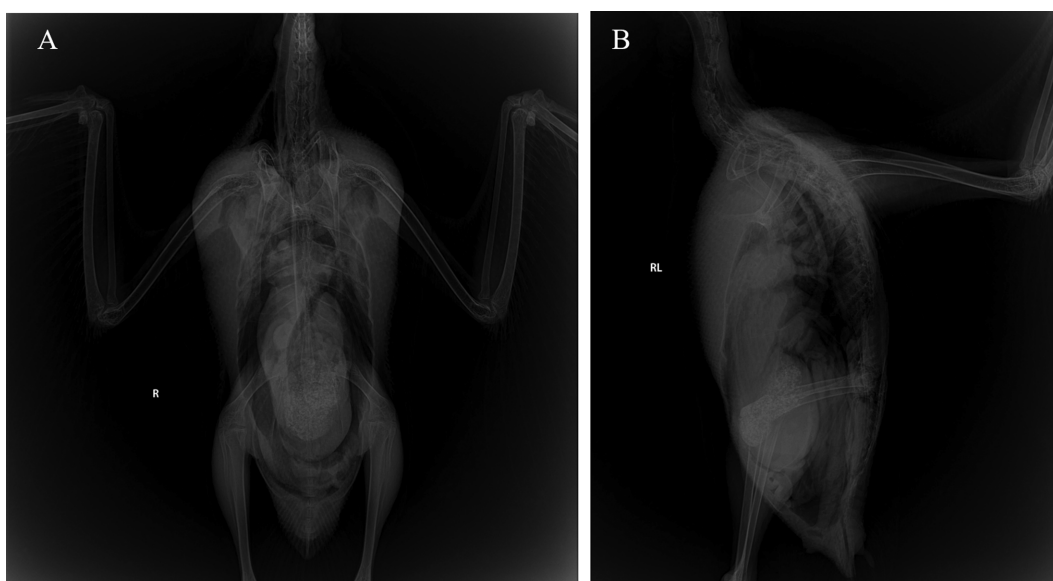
No remarkable findings were observed on radiographic examination. Ventro-dorsal view (A). Right lateral view (B).
